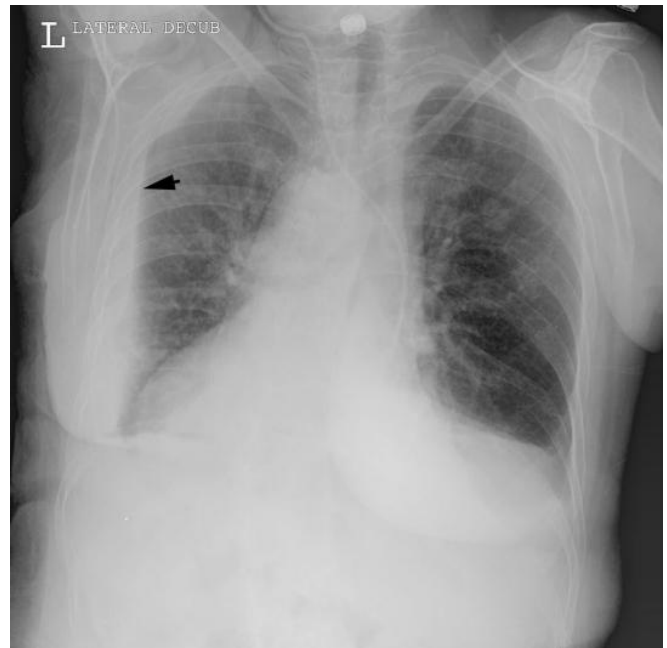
Left lateral decubitus radiograph showing a layering of a small pleural effusion. Arrowhead points to the layer of fluid.
